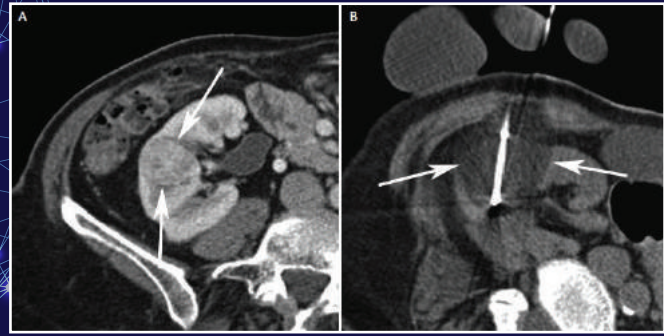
Contrast-enhanced CT scan showing a complex enhancing tumour (arrow) in the lower pole of the left kidney. No hilar, vascular or lymph node involvement is evident.
